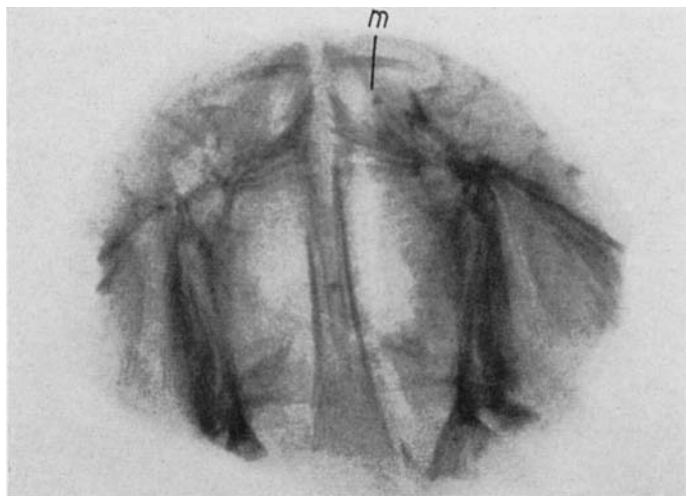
Roentgenograph of the maxilla of a 6-month-old human foetus. The incisal edges of the first incisors are seen as two straight darker bands near the upper margin of the picture. A median plane designated by the letter »m» has been drawn on one of the germs.
